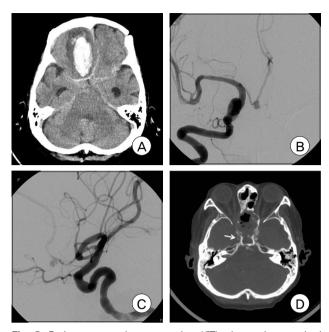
Brain computed tomography (CT) shows intracerebral and subarachnoid hemorrhage (A). Angiography reveals an aneurysm of the anterior communicating artery (B and C). A source image of CT angiography shows luminal narrowing and irregularity in the petrous and lacerum segments of the right internal carotid artery (D).
